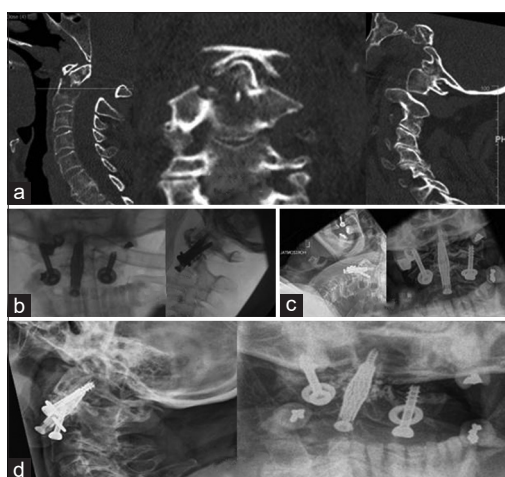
Case 2- comminuted and posteriorly angulated type 2 odontoid peg fracture with atlanto-axial instability (a). Intra-operative (b) and immediate post-operative (c) pictures showing reconstruction of defect and stabilisation of atlanto-axial joint. 6 month post-operative radiograph showing loose left transarticular screw but maintained reduction and fixation of odontoid peg (d)
